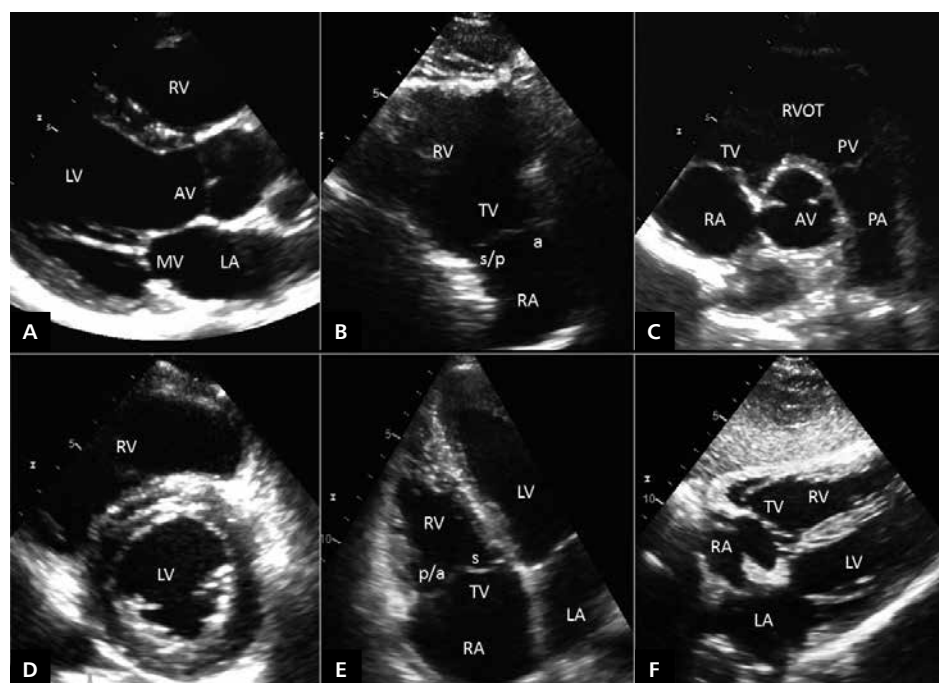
Recommended echocardiographic views for the assessment of the right ventricle (RV); A. Parasternal long-axis view demonstrating the RV anterior wall and proximal part of the right ventricular outflow tract (RVOT); B. Parasternal long-axis view of RV inflow visualising anterior and inferior walls of the RV, RV inflow tract, and two leaflets of the tricuspid valve (TV) (a — anterior leaflet of TV; p — posterior leaflet of TV; s — septal leaflet of TV); C. Parasternal short-axis view of RVOT and pulmonary artery (PA) showing basal part of RV anterior wall, RVOT, two leaflets of the TV, pulmonary valve (PV), and PA; D. Parasternal short-axis view at the level of papillary muscles used for the evaluation of the RV crescent shape, calculation of the eccentricity index, and assessment of the interventricular septum motion; E. RV-focused apical four-chamber view used to assess the inflow and apical part of the RV, RV lateral wall, interventricular septum, and leaflets of the TV (septal and posterior in the vast majority of patients); F. Subcostal four-chamber view visualising the RV inferior wall; AV — aortic valve; LA — left atrium; LV — left ventricle; MV — mitral valve; RA — right atrium
